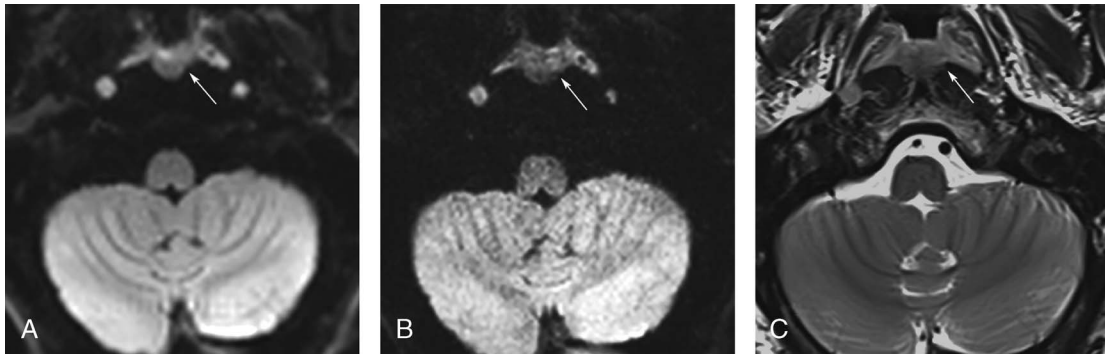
At the same level, RS-DWI (A), SMS-RS-DWI (B), and TSE-T2WI (C) show a mass that mainly involved the nasopharynx (white arrow). There is almost no distortion observed on DWI compared with T2WI.
